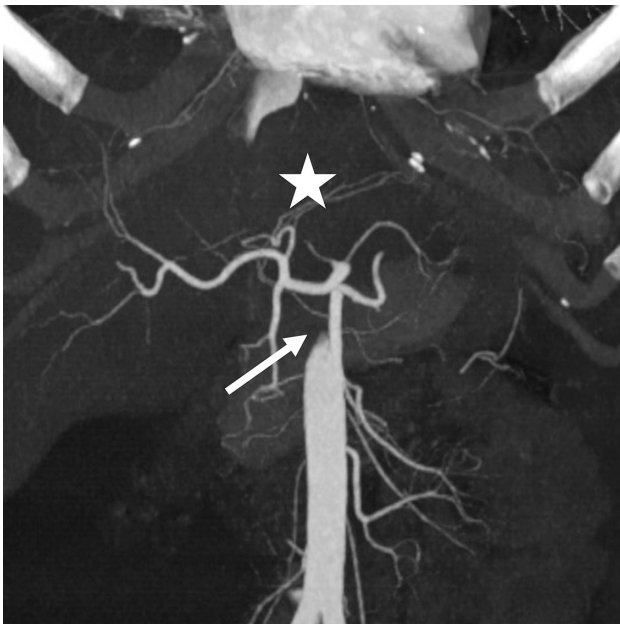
Coronal-view reconstructive contrast-enhanced abdominal computed tomography image.
